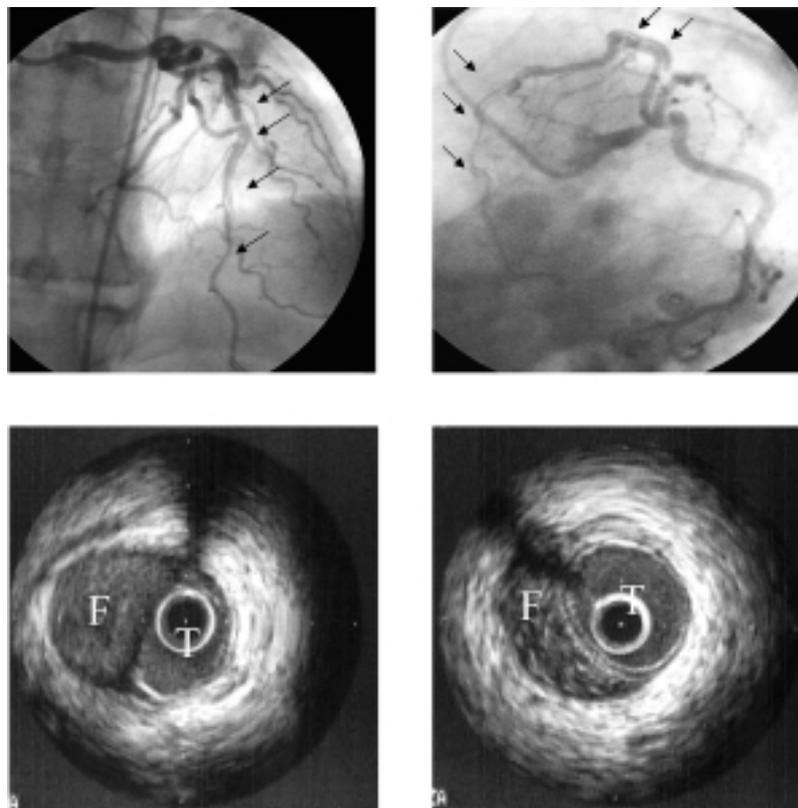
Upper left panel: antero-posterior cranial projection (30°) showing a long dissection of the left anterior descending coronary artery and involving a diagonal branch (arrows). Upper right panel: the spider view showed the dissection of the left anterior descending coronary artery originating from the mid segment (arrows) and causing severe distal stenosis. Lower left panel: intravascular ultrasound imaging. True (T) and false (F) lumina (intramural hematoma) at the level of the mid segment of the left anterior descending coronary artery. Lower right panel: intravascular ultrasound imaging. T and F lumina in the distal segment of the mid left anterior descending coronary artery.
